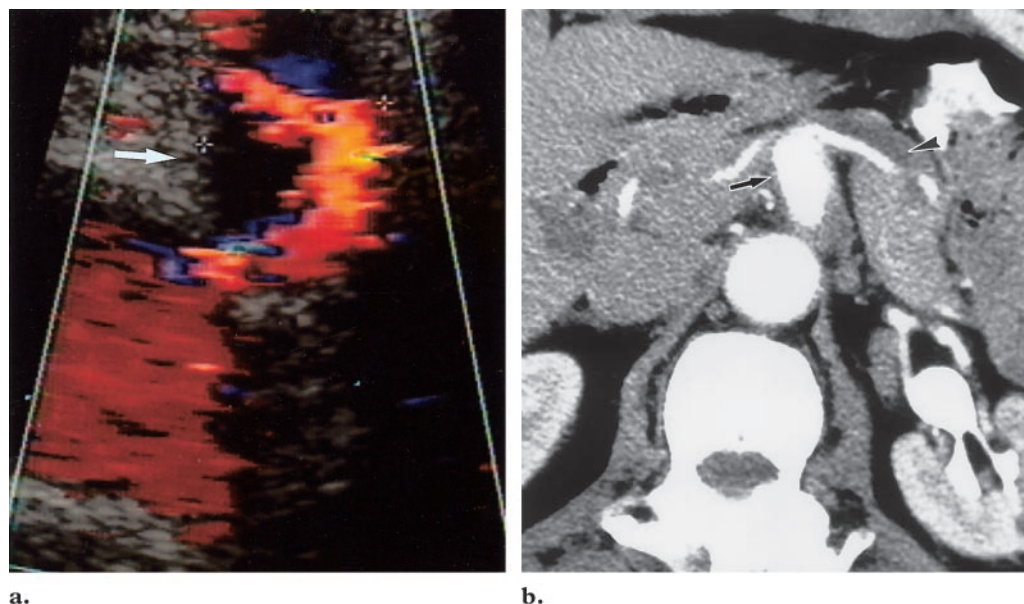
Aneurysmal dissection of the CA in a 59-year-old patient who had severe epigastric pain for several years. (a) Color Doppler US image shows an aneurysm of the celiac trunk (arrow). (b) Contrast-enhanced CT scan also shows the aneurysm (arrow). The very thin aspect of the splenic artery and the hypoattenuating crescent anterior to the splenic artery (arrowhead) are suggestive of an associated splenic artery dissection.
